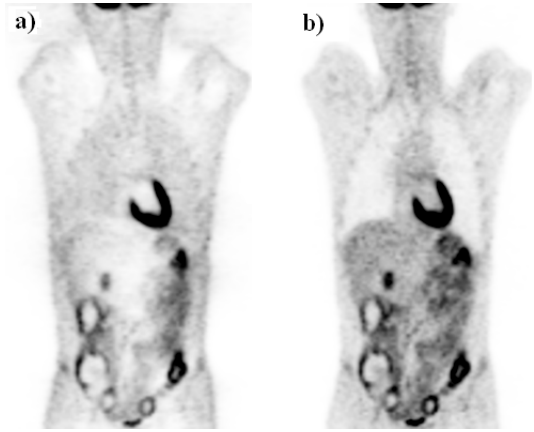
Whole-body FDG PET images a) before and b) after correction for attenuation. Differences can be seen most clearly in the lungs and in the centre of the dense sub-diaphragmatic tissues
